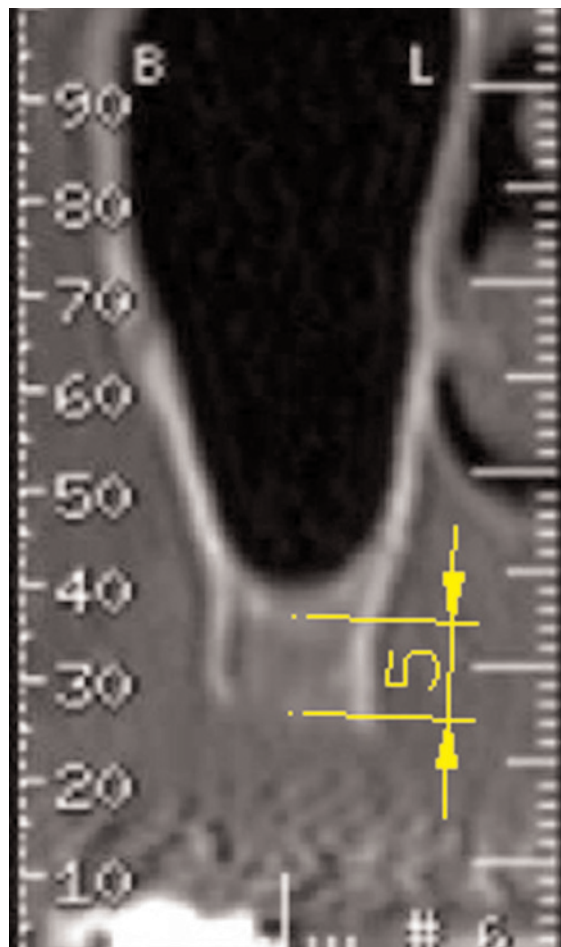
Preoperative CT scans used to screen eligibility of patients with bilateral atrophic posterior maxilla: 4 to 6 mm of bone height and at least 8 mm thick below the maxillary sinus was required.
